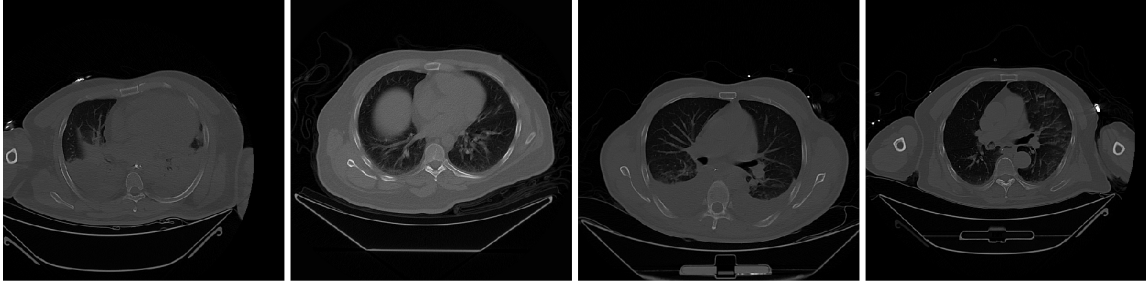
Raw CT data from 4 subjects taken at the 4th intercostal space. This image highlights the challenges with automatic segmentation of the lung and external boundary. In some subjects the external boundary is obscured by the arms, and in other subjects the true lung boundary is masked by occlusions.
